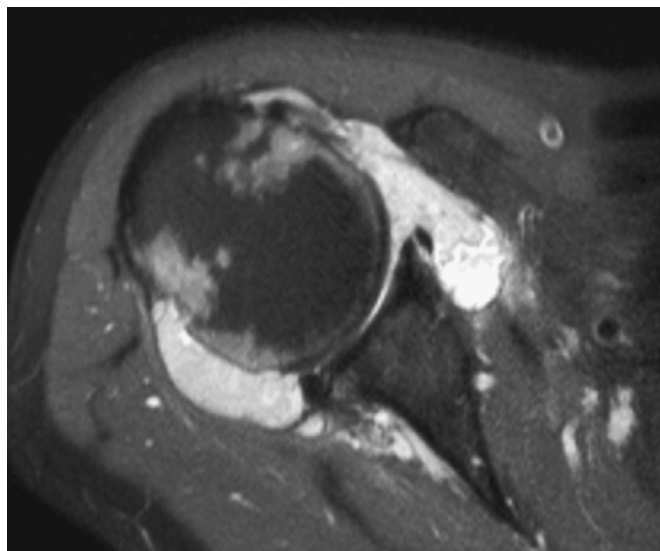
A T1-weighted and gadolinium-enhanced magnetic resonance image of the same patient as in Figures 20-15 and 20-22 shows anterior and posterior synovitis.
